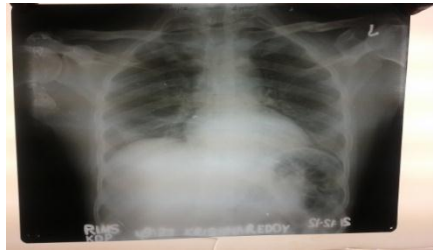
Chest X-ray shows that interstitial lung disease shows linear and reticular pattern, superimposed upon the ground-glass attenuation in the basal region of lung and mild cardiomegaly.
